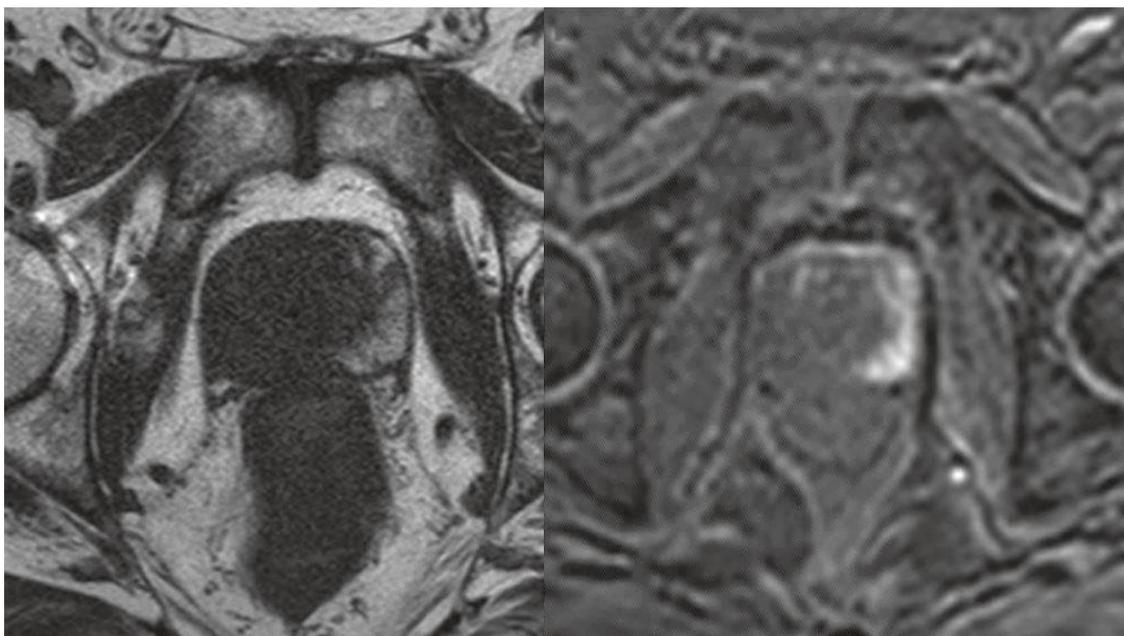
Post biopsy haemorrhage area showing hyperintensity in T1-weighted sequences in the left peripheral zone. First, axial turbo spin-echo T1-weighted sequence. Second, precontrast fat-suppressed fast-field-echo T1 weighted sequence. Obtained from (8).
